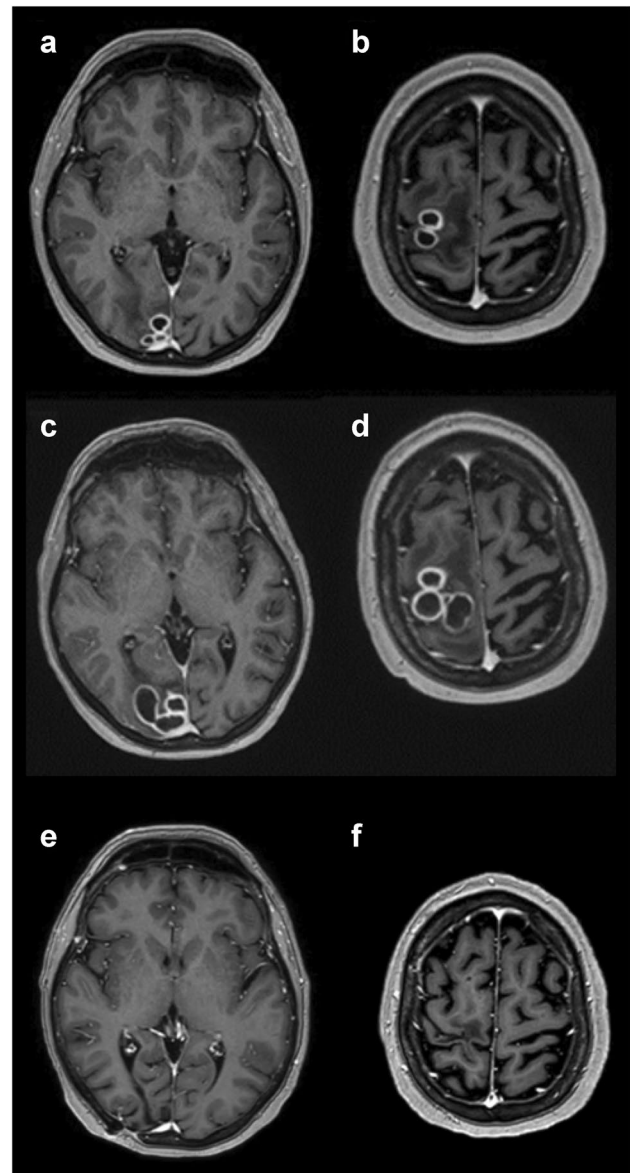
Brain MRI (1,5T), axial contrast-enhanced T1w turbo field echo (TFE) images. Multiple cortical-subcortical rim-enhancing cerebral lesions located in the occipital lobe parasagittal area (A) and in the frontal lobe at the vertex (B). Later scans after 37 days showing lesions growth (C–D). Follow-up imaging after 28 months showing no contrast enhancement in the previously affected areas. Residual mild encephalomalacia in the occipital lobe parasagittal area (E) and gliosis in the frontal lobe at the vertex (F)
